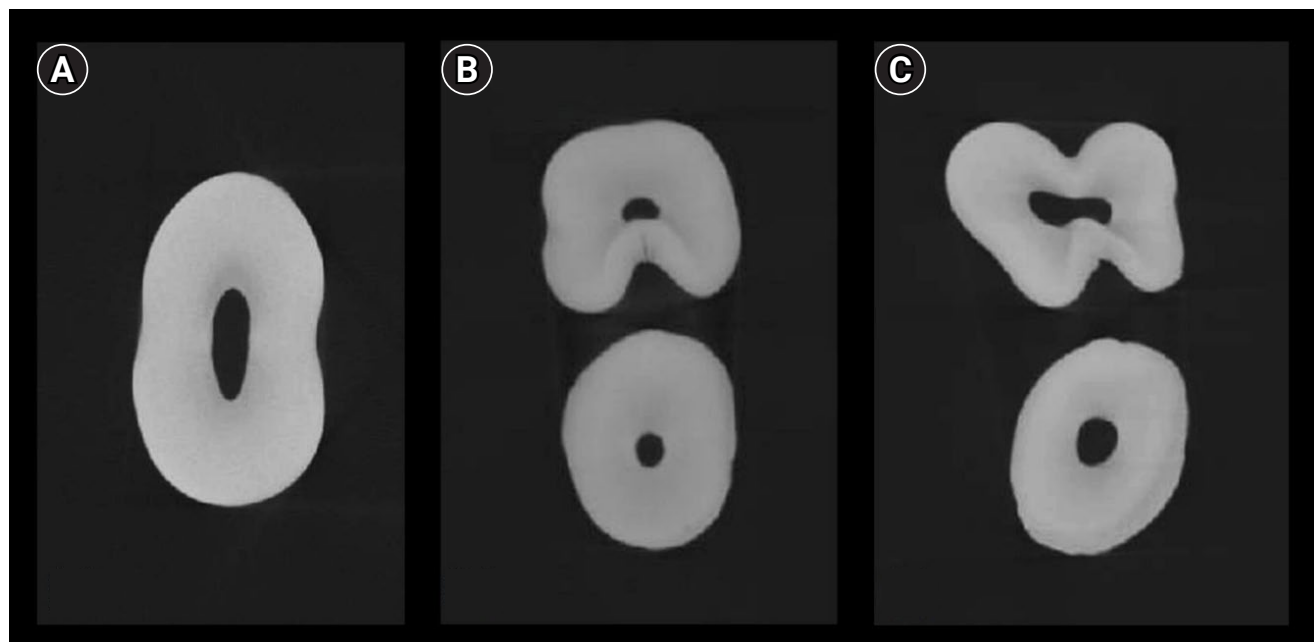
Micro-computed tomography images showing the morphological variations in the axial sections of maxillary premolars: (A) single-rooted; (B) double-rooted with a furcation groove in the palatal aspect of the buccal root; and (C) double-rooted with developmental grooves in the buccal and palatal aspects of the root.
